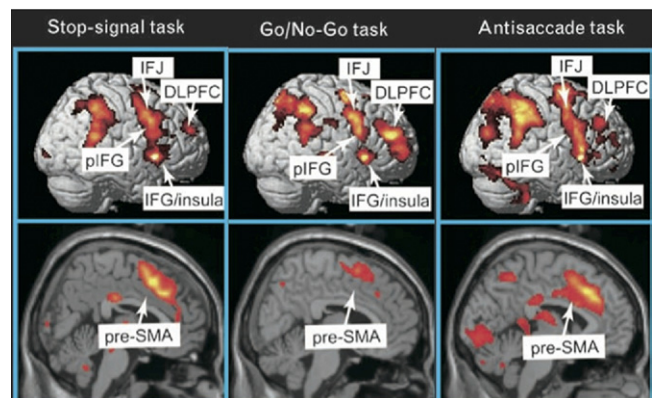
Functional magnetic resonance imaging studies of stop signal and related paradigms. The “stopping network” in the cortex is activated by different control tasks and is predominantly right-lateralized including the presupplementary motor area (preSMA), and the right inferior frontal cortex (rIFC). Right IFC activity is broadly distributed and may reflect an inferior frontal junction (IFJ) component, a more ventral posterior inferior frontal (inferior frontal gyrus, pIFG; putatively implementing inhibitory control), and an insula region of unknown function. Maps of the activation during performance of go/no-go, stop signal, and antisaccade tasks were revealed by contrasting no-go versus frequent-go, stop versus go, and antisaccade versus baseline-saccade trials, respectively, see Chikazoe (16) for further details. Reprinted with permission from Chikazoe J (2010): Localizing performance of go/no-go tasks to prefrontal cortical subregions [published online ahead of print March 10]. *Curr Opin Psychiatry* (33).
